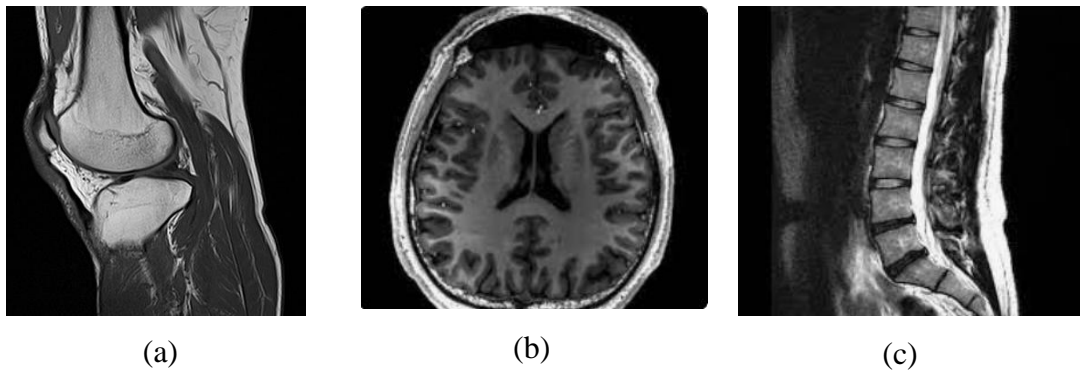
(a) Knee MRI medical image, (b) Brain MRI medical image, (c) Spine MRI medical image [8]
